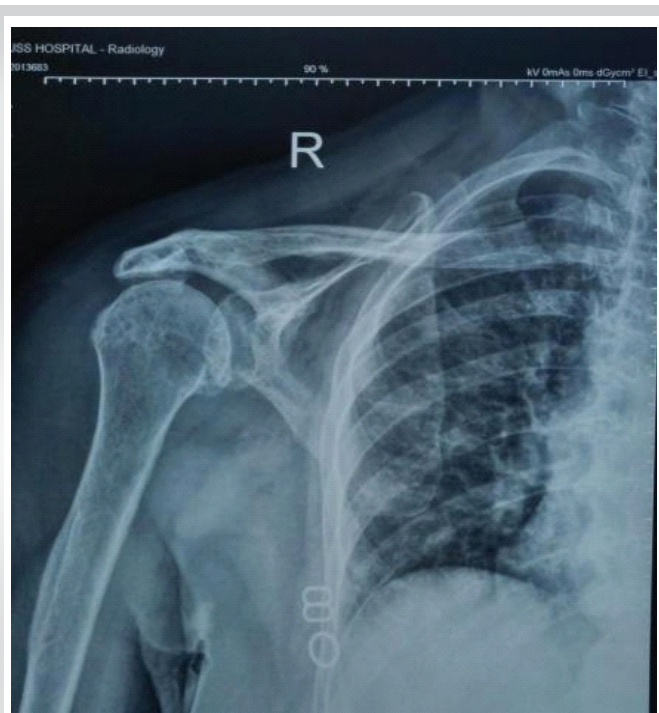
Pre-operative and post-operative radiographs of the right shoulder. (a) Pre-operative radiograph showing degenerative changes consistent with rotator cuff arthropathy.
